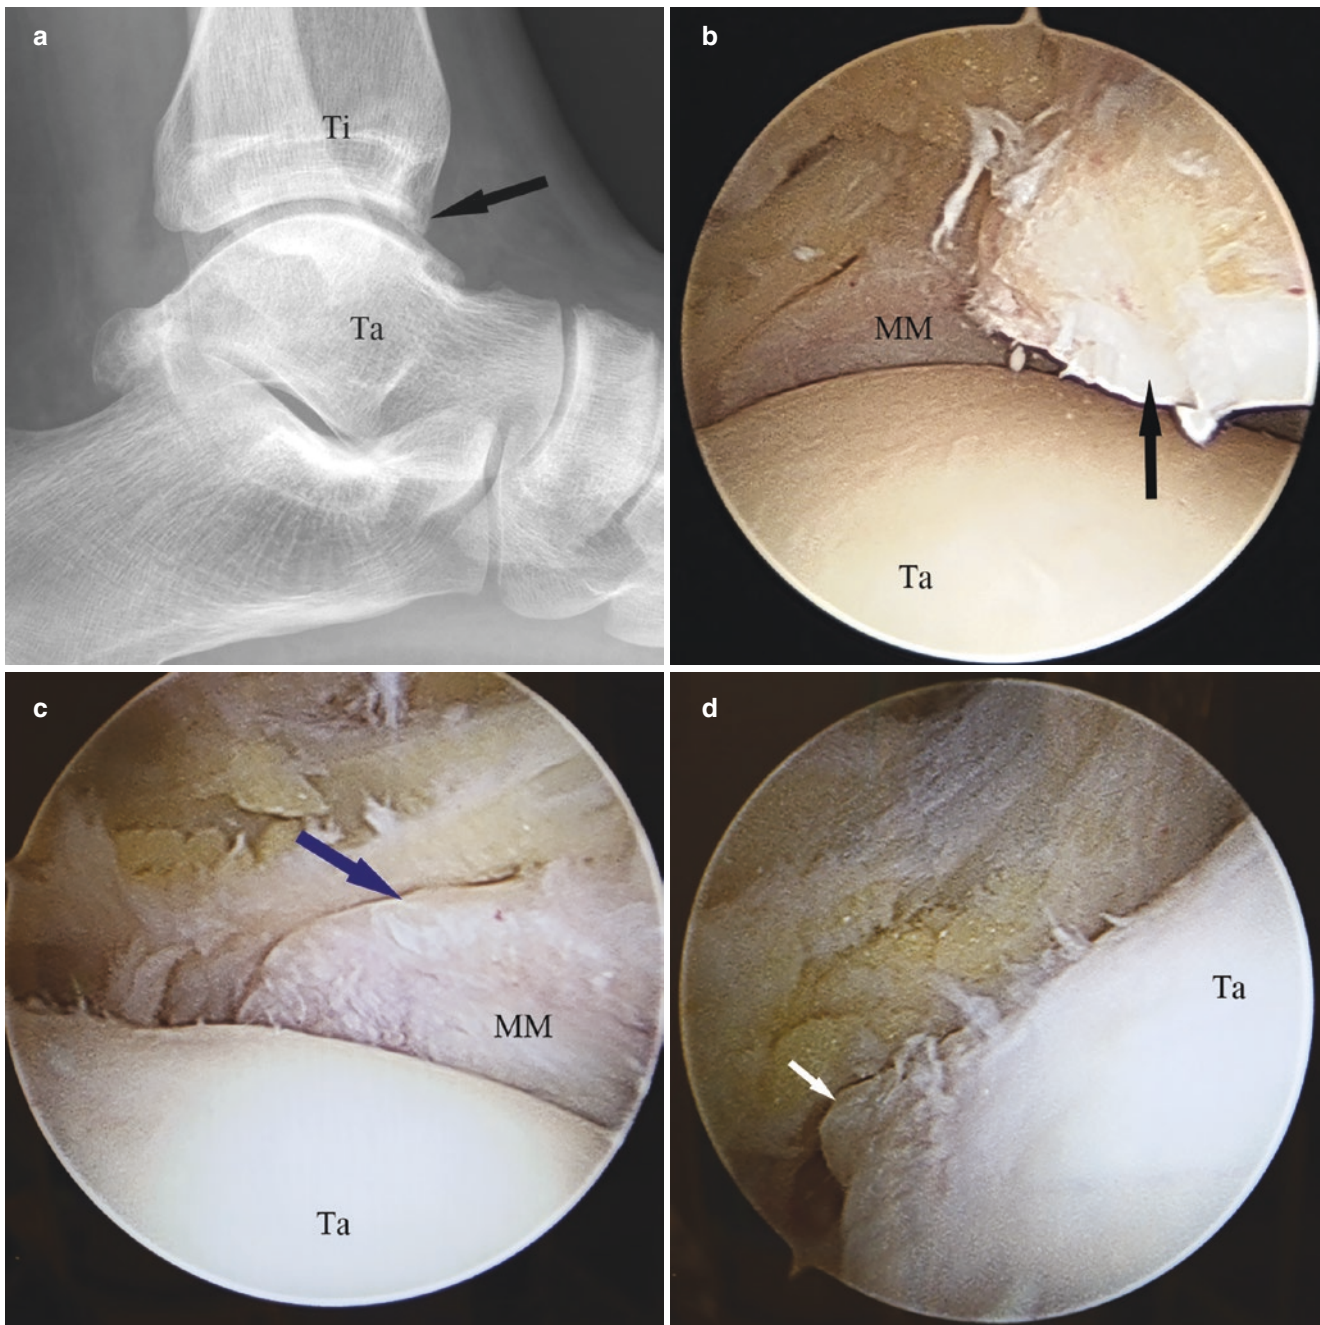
Anteromedial osteophyte. (a) Lateral X-ray of the ankle. (b) Anteromedial osteophyte of the tibia (black thick arrow). (c) Hypertrophy of the medial malleolus (blue thick arrow). (d) Anteromedial margin of the talus (white thick arrow). *MM* medial malleolus, *Ta* talus, *Ti* tibia
